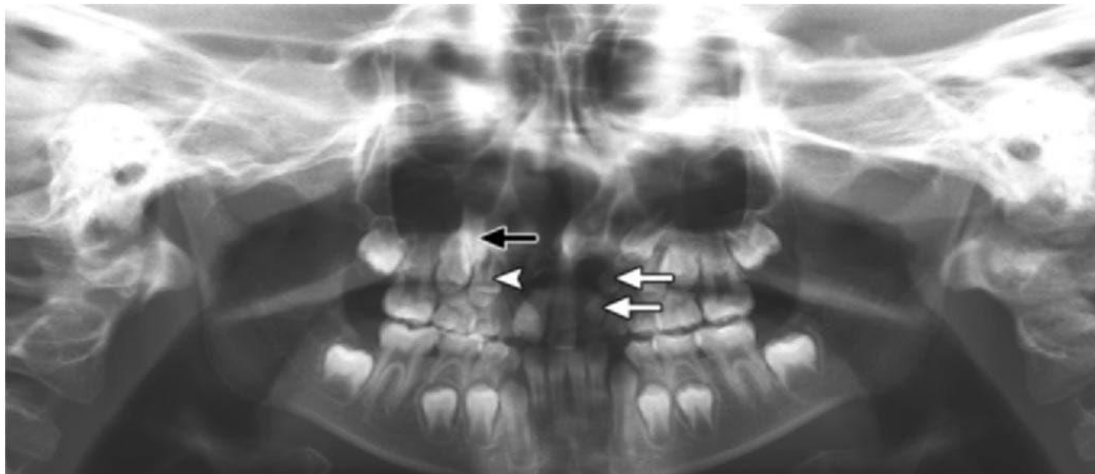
Panoramic radiograph: Cleft palate alveolus. (Zachary2015).
